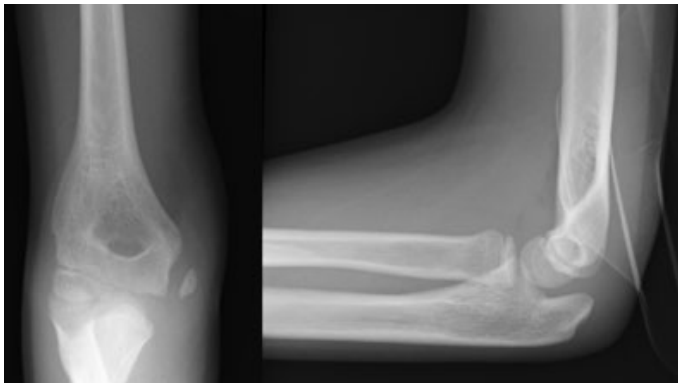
Initial injury x-rays.
